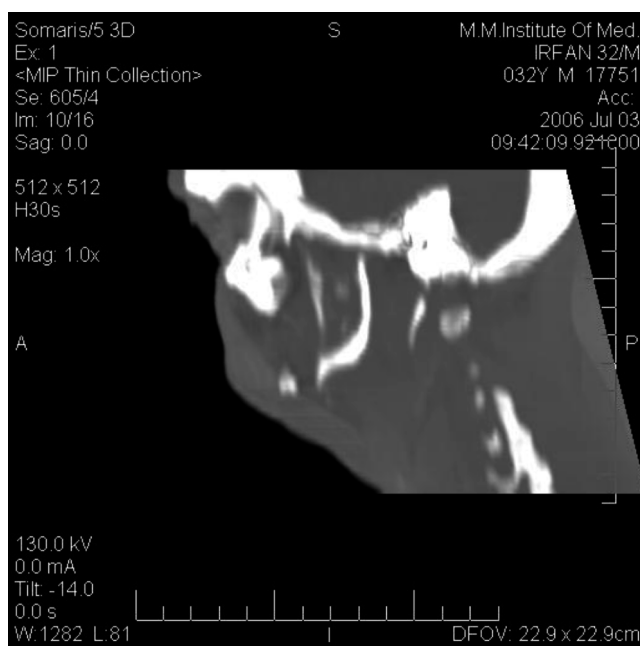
CT image showing remnants of resorbed mandibular condyle.
